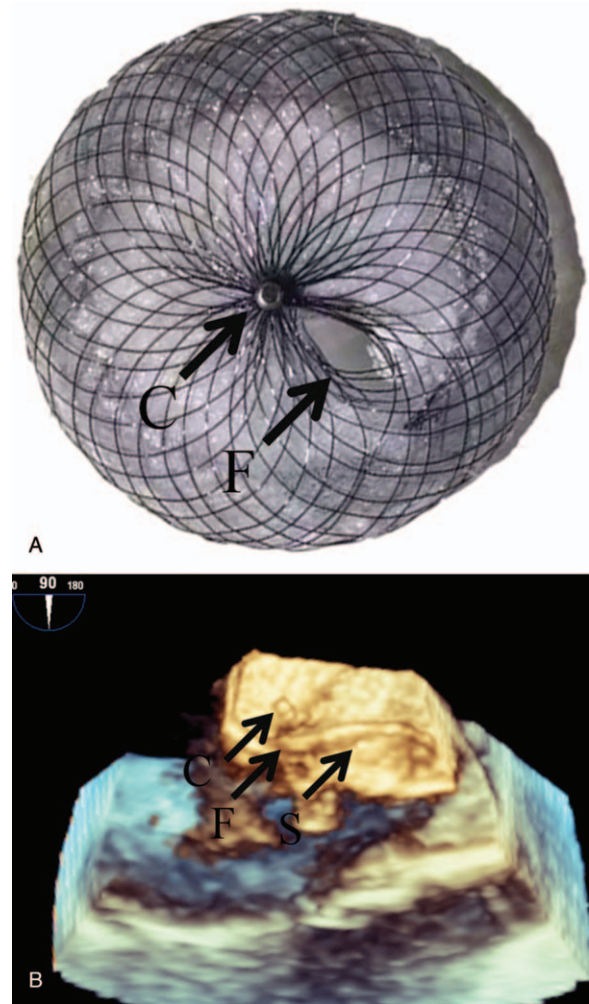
Actual Memory ASD fenestrated device and 3-dimensional transesophageal echocardiography (TEE) imaging: (A) Fenestration next to the center hub (arrows), (B) Position relationship among center hub fenestration and the sheath (arrows). C=center hub, F=fenestration, S=sheath.
